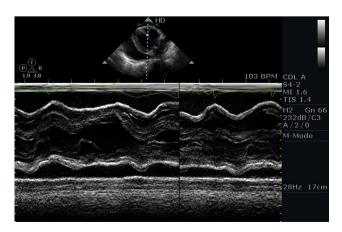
Parasternal long axis view showing RV diastolic collapse suggestive of collapse.
